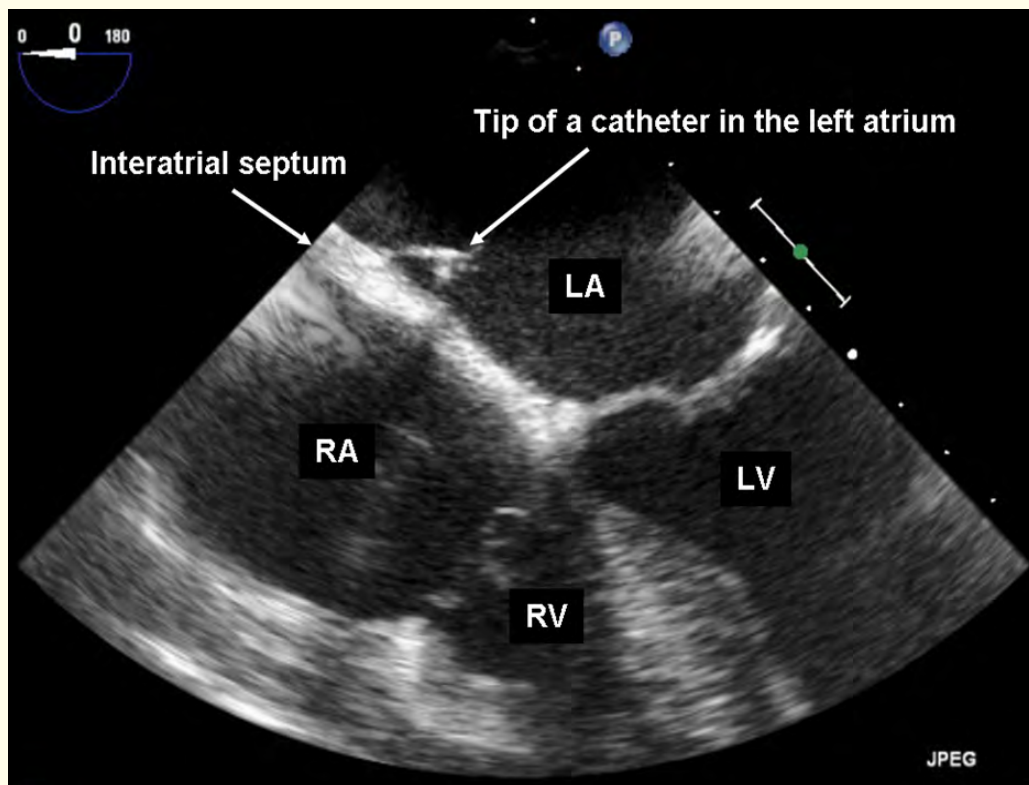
Echocardiography guided transseptal puncture. The catheter crossing the interatrial septum with its tip in the left atrium is demonstrated on the transesophageal echocardiogram in the mid-esophageal view at 0 degrees.
